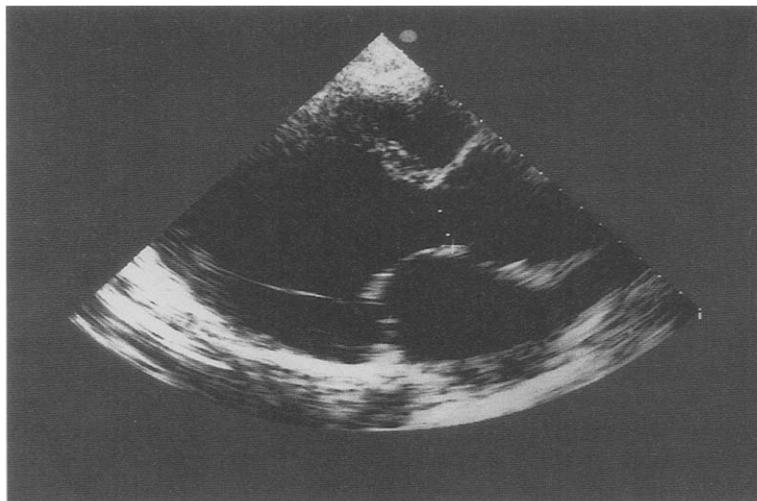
Preoperative echocardiogram showing aortic root dilation and thin, pliable aortic valve leaflets with central lack of coaptation.
